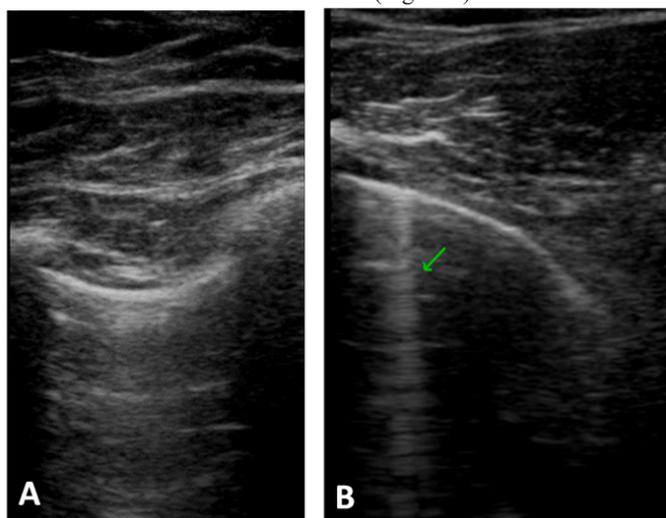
The score lung ultrasound evaluation in mixed connective tissue disease patient with a total of B-lines to equal 7: (A) Left anterior-axilar recess, without B-line; (B) Right paravertebral recess, with B-line (arrow).
